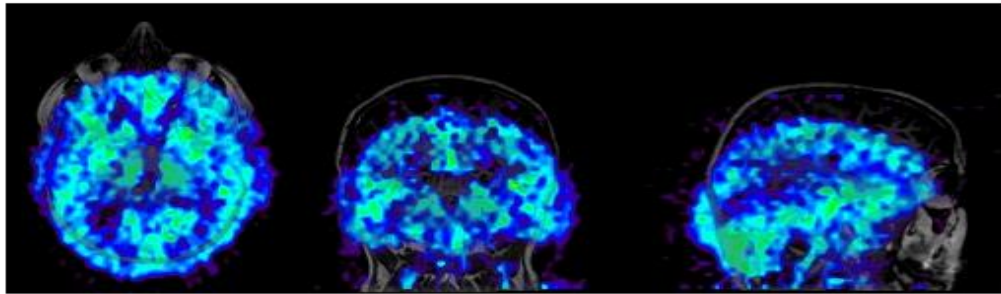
Coloured PET Water Dynamic Images with Black and White MRI Images Superimposed.
